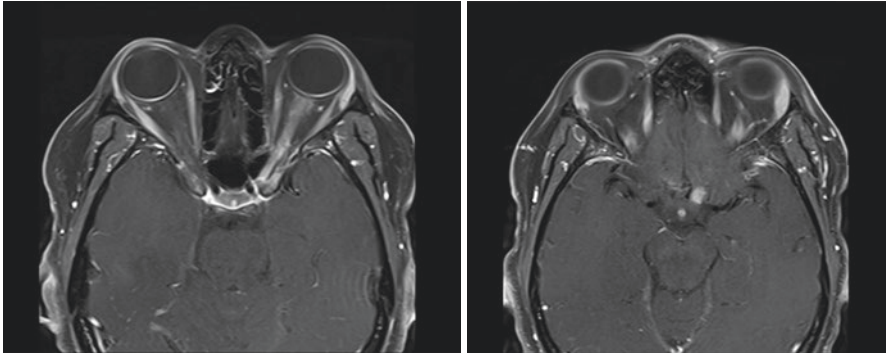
Axial T1-weighted post-contrast MRI demonstrates longitudinally extensive enhancement of the left optic nerve including the retrobulbar, intracranial, and prechiasmatic (intracranial) segments (© AD Henderson 2021. All Rights Reserved)
